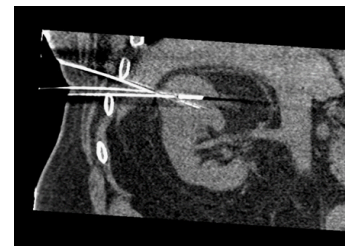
Coronal oblique CT reconstruction showing path of probes through liver edge.
